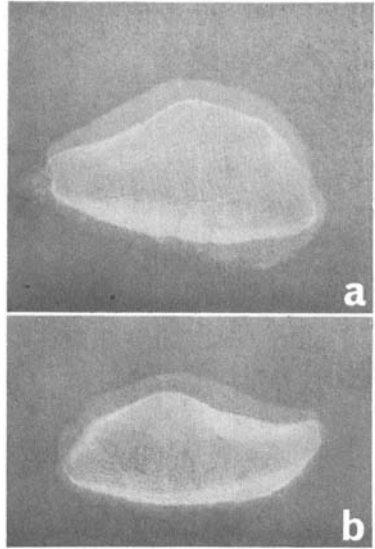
a. X-ray film of slices sawn proximally and distally from the same patella originating from a 49-year-old woman. The curve and the termination medially of the medial joint surface differ on the two slices. The distal one shows cartilaginous changes. b. X-ray film of a patellar slice from a 47-year-old woman. Cartilaginous changes on both articular facets, most pronounced laterally. Osteophyte formation medially as well as laterally.
